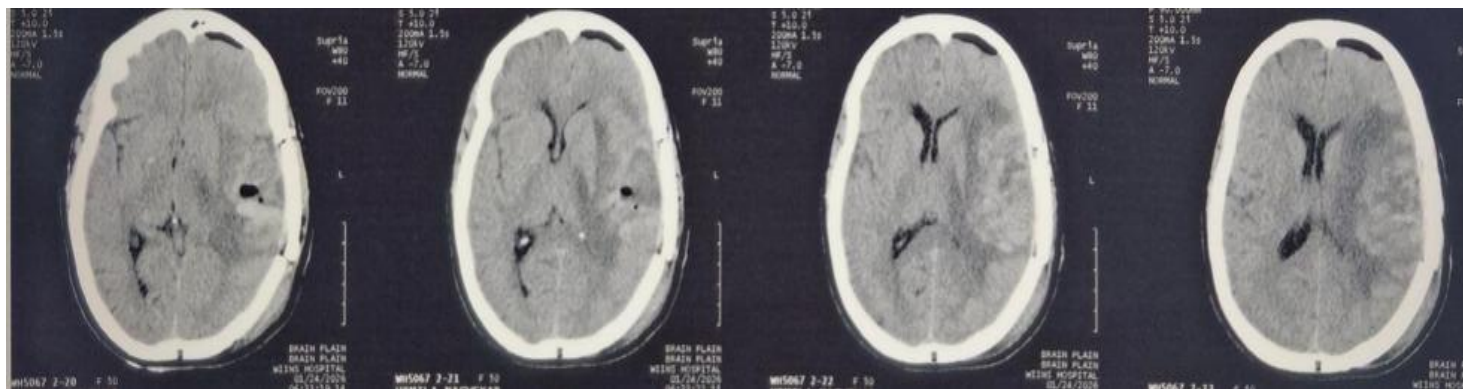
Post-op CT Brain.
